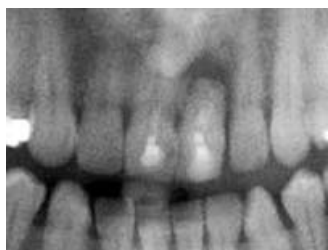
Radiographic view of Case 1.
